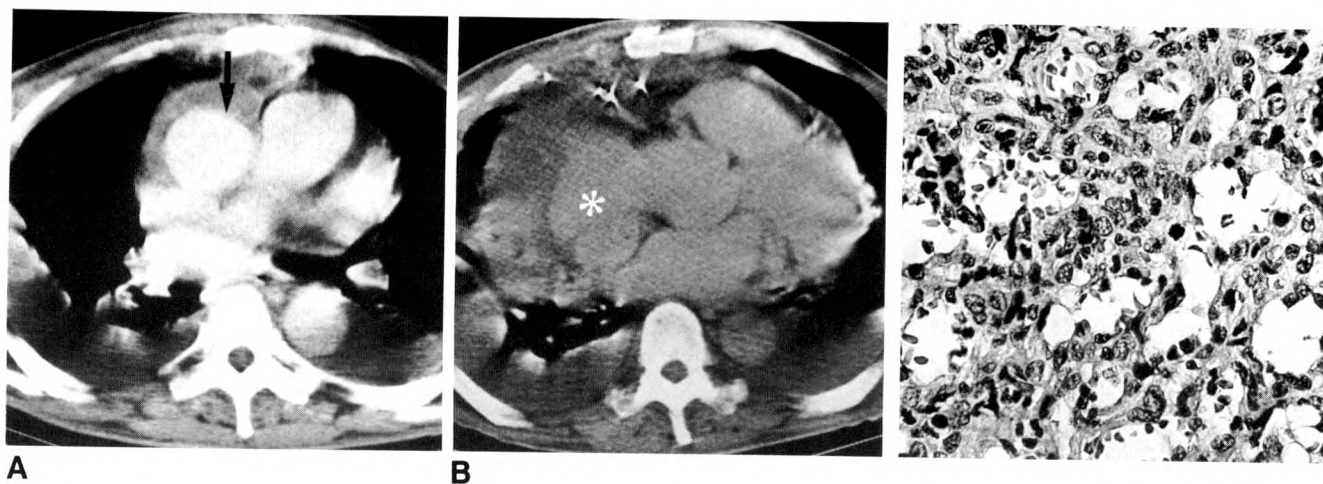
A and B, CT scans through the heart (A more cephalad than B) after IV administration of 150 ml of contrast media shows a large mass in direct connection with the right atrium (white asterisk in B) protruding into the pericardium (B) and encasing the aortic root (arrow) (A). Note also pericardial thickening and effusion and bilateral pleural effusion.
